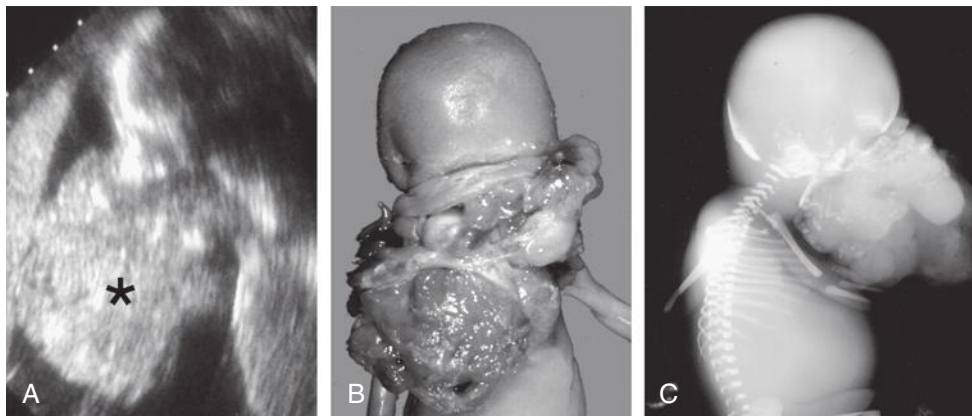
Epignathus: A, Antenatal sonogram demonstrating a large mass (*asterisk*). B and C, Postnatal images in a similar case. (B and C courtesy of Frank Chervenak, MD, New York, NY, and www.TheFetus.net).
